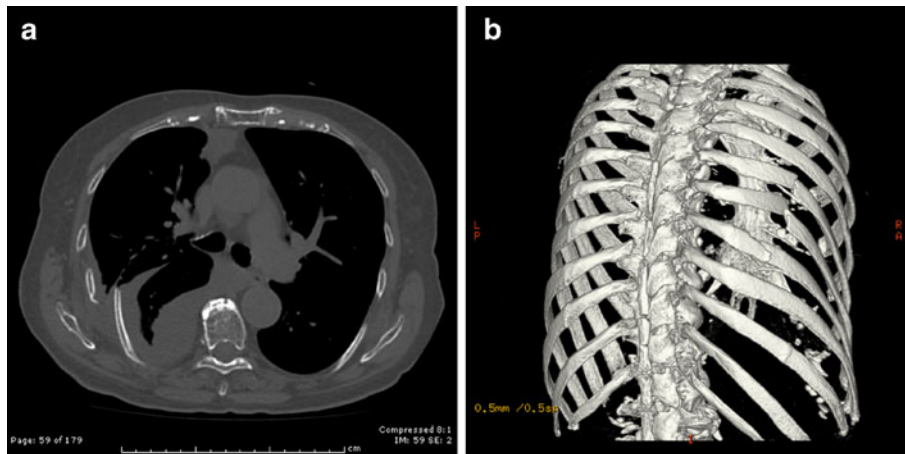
A Axial computed tomography cut showing a large right-sided effusion with significant internal rotation and displacement of the posterior rib fractures. B 3-D computed tomography reconstruction depicting the right-sided rib fractures. No true flail segment is seen
